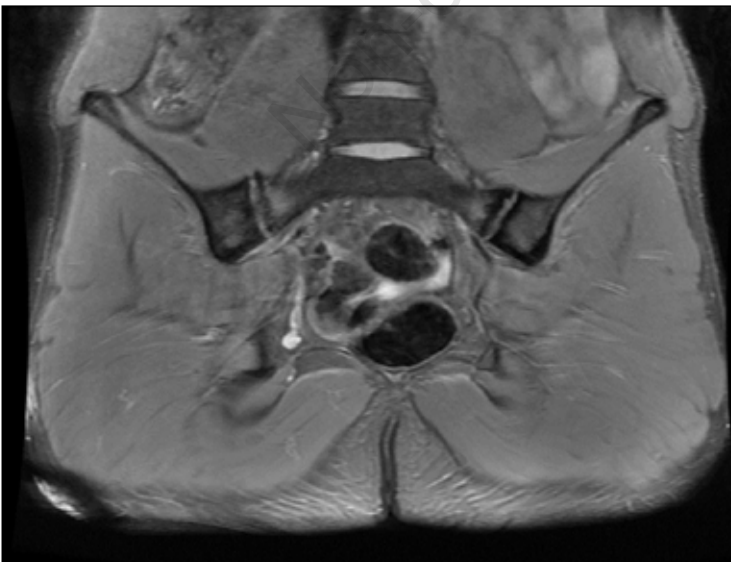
Magnetic resonance imaging with fat saturation of the pelvis showing bilateral sacroiliitis with evidence of subchondral sclerosis, edema, and erosions.
